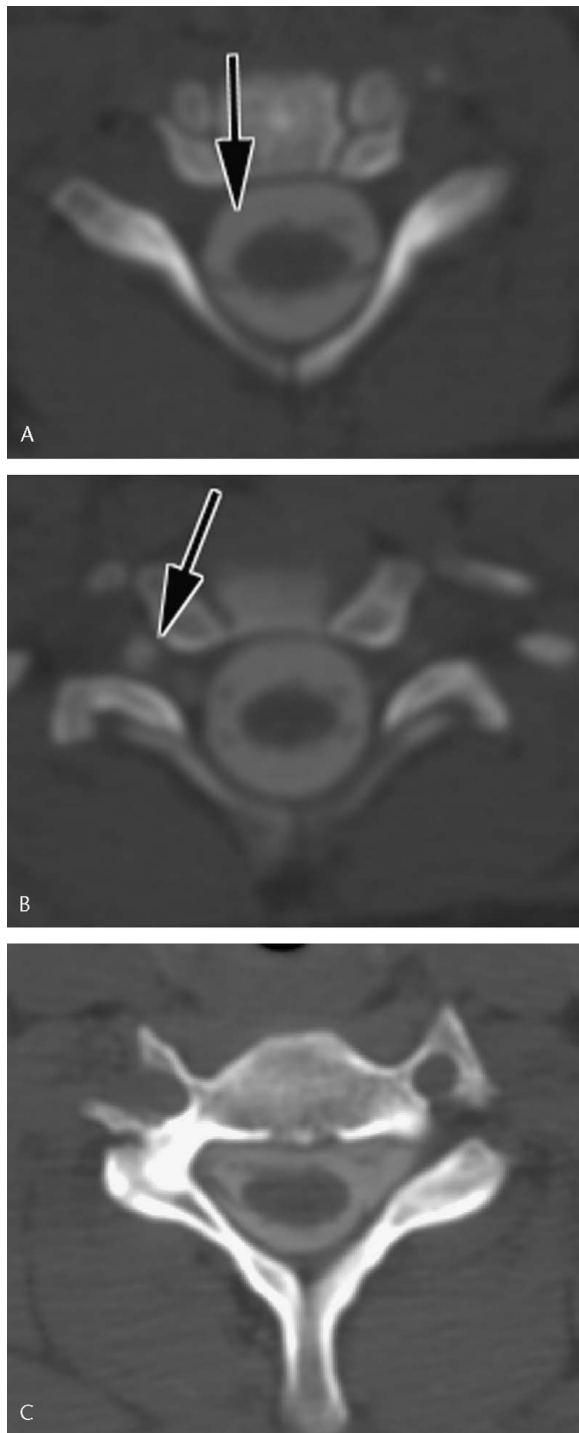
Nerve root avulsions in two patients. A, Axial image from a CT myelogram demonstrates right ventral nerve root avulsion in a newborn, status post birth trauma (arrow, expected location of the right ventral nerve root at this level). B, An additional image from the same study demonstrates resultant pseudo-meningocele. C, Axial image from a CT myelogram from an adult demonstrates post-traumatic ventral and dorsal nerve root avulsions on the left.
